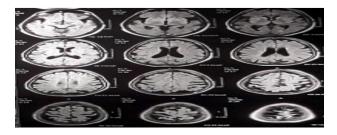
MRI brain showing generalized atrophic changes.
